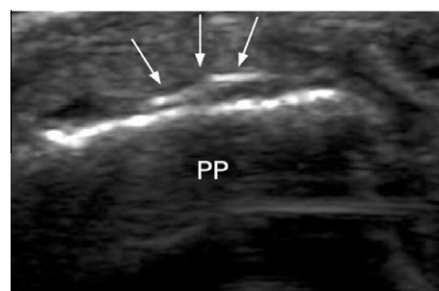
Dorsal longitudinal view of the proximal interphalangeal joint on ultrasonography, showing osteophytes (arrows).
